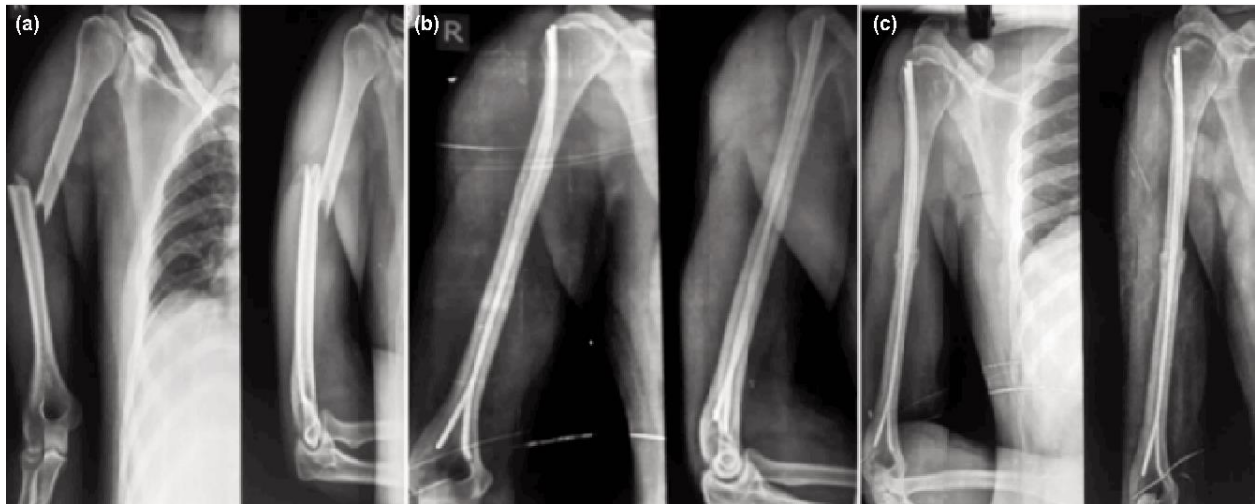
X-Ray of Titanium Elastic
